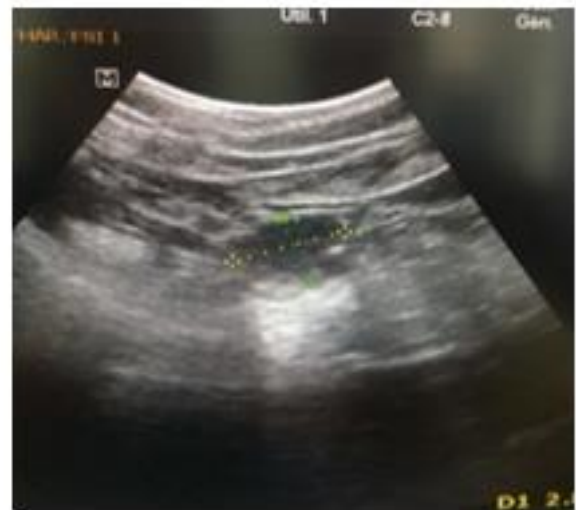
Ultrasound Appearance
